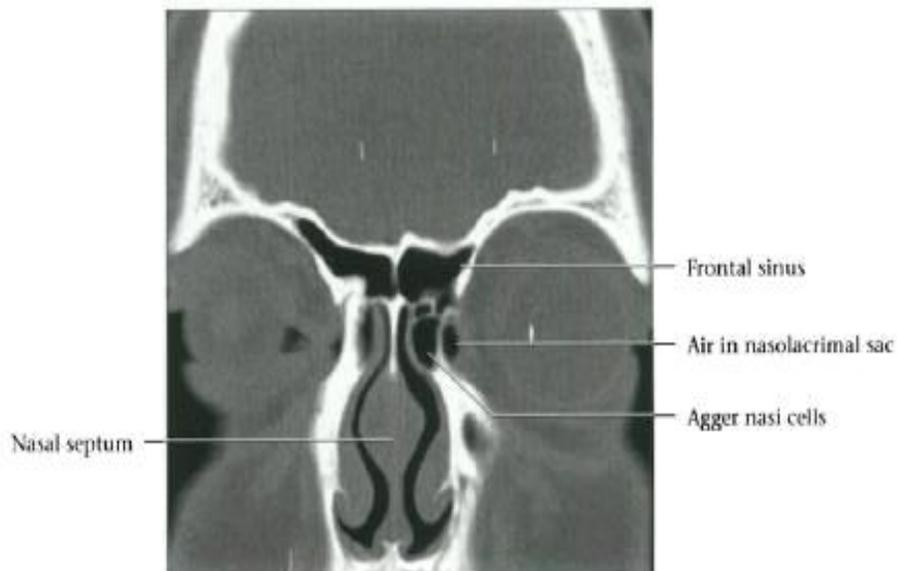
Coronal CT bone window shows the frontal sinuses, agger nasi air cells. Notice the normal air-filled left nasolacrimal sac (Harnsberger et al., 2006).
